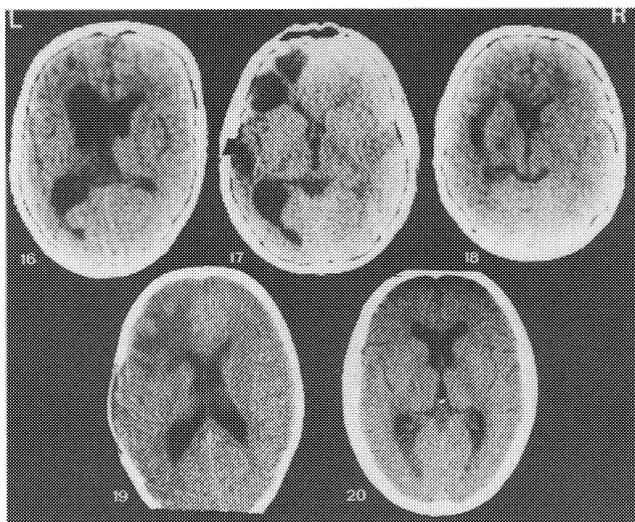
CT-scans of five patients with infectious disease. The numbers correspond to the case numbers in Table 1.
